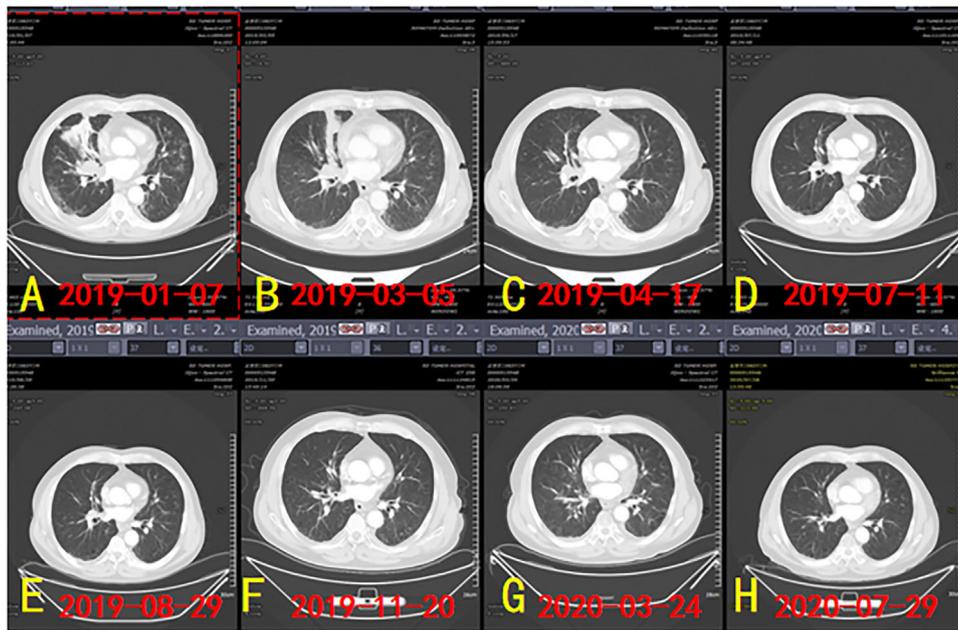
(A) CT image before anlotinib treatment. (B–H) CT images after anlotinib treatment
